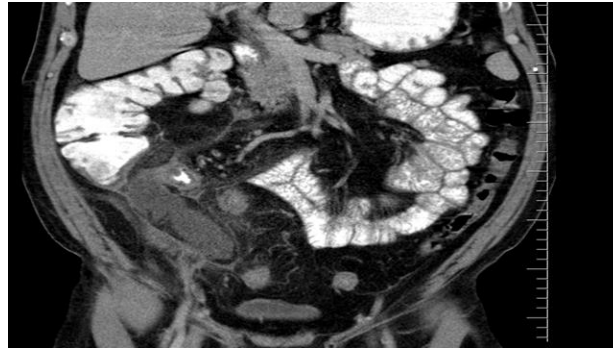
The arrow pointing to the lesion in a coronal section in a CT scan.
